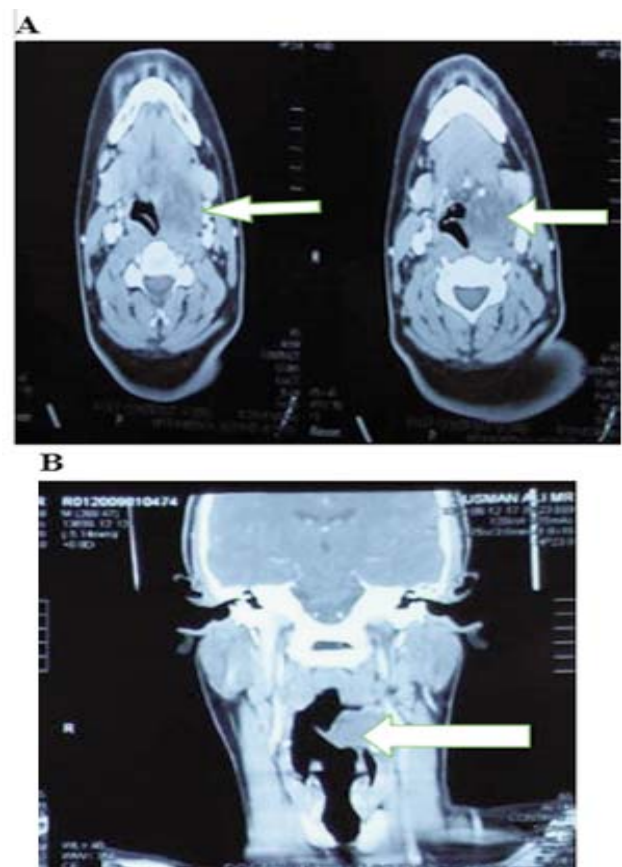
(a) CT Scan of the neck (axial view) reveals well-defined lesion attached with the left half of the hyoid bone causing narrowing of oropharynx. (b) CT Scan coronal view reveals lesion arising from the left half of the hyoid bone.
